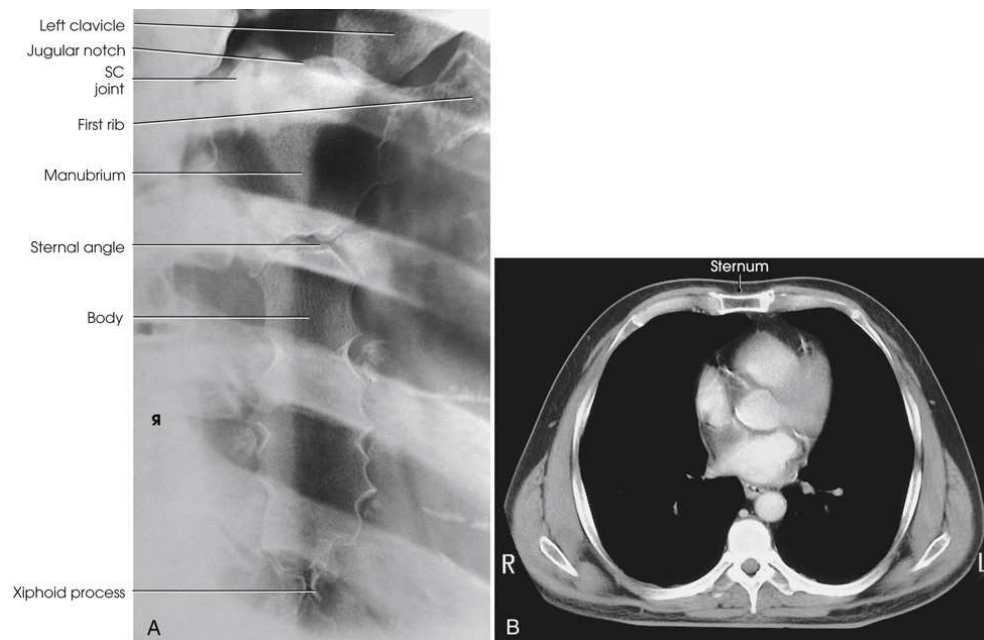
(A) PA oblique sternum, RAO position. (B) CT is often used today to image the sternum. Image shows sternum in axial plane. B, Modified from Kelley LL, Petersen CM. *Sectional anatomy for imaging professionals*, 2nd ed. St. Louis: Mosby; 2007.
